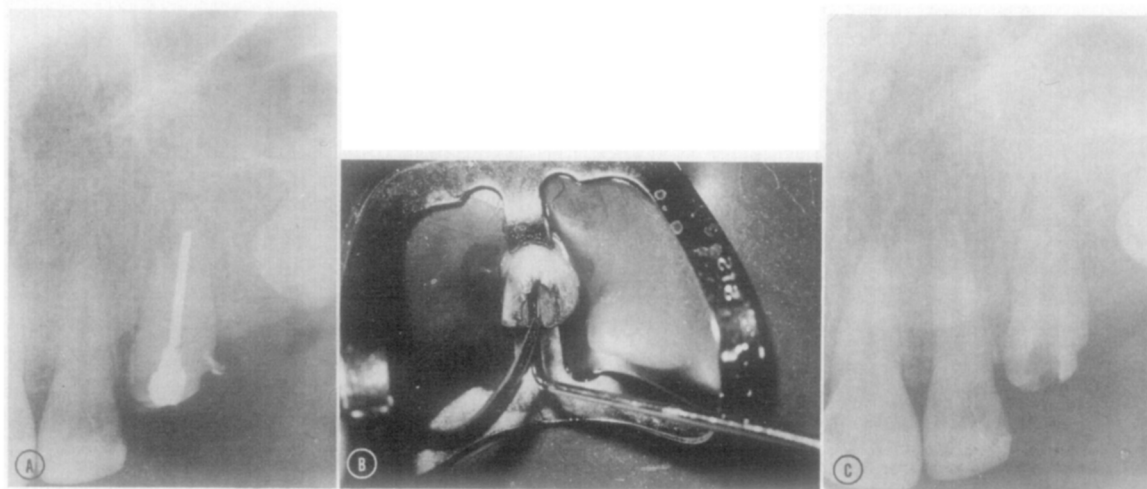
Removal of firmly fitted silver point to enable placement of gutta-percha prior to post preparation. A, Preoperative radiograph. B, Explorer placed parallel to silver point with ultrasonic probe in contact. C, Silver point removed.
